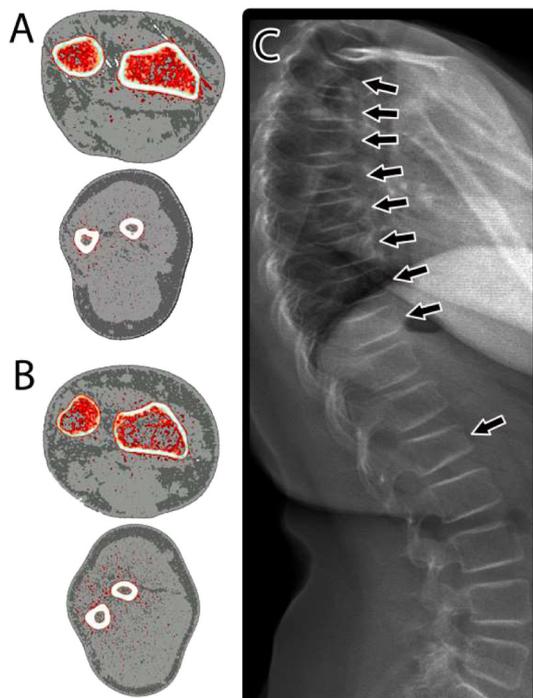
(A) Forearm peripheral quantitative computed tomography scans at the metaphysis (upper panel) and diaphysis (lower panel) of a 41-year-old healthy woman (trabecular volumetric bone mineral density of the radius: 200 mg/cm³; z-score + 0.6). (B) Corresponding scans of a 42-year-old woman with a missense variant in *LRP5* (p.Glu1094Lys; trabecular volumetric bone mineral density 111 mg/cm³; z-score – 2.6). Results at the diaphysis are within normal limits. (C) Lateral spine radiograph of 7-year-old daughter of proband shown in (B), with compound heterozygous *LRP5* variants (p.Arg1036Gln and p.Glu1094Lys). Multiple vertebral compression fractures (arrows).
